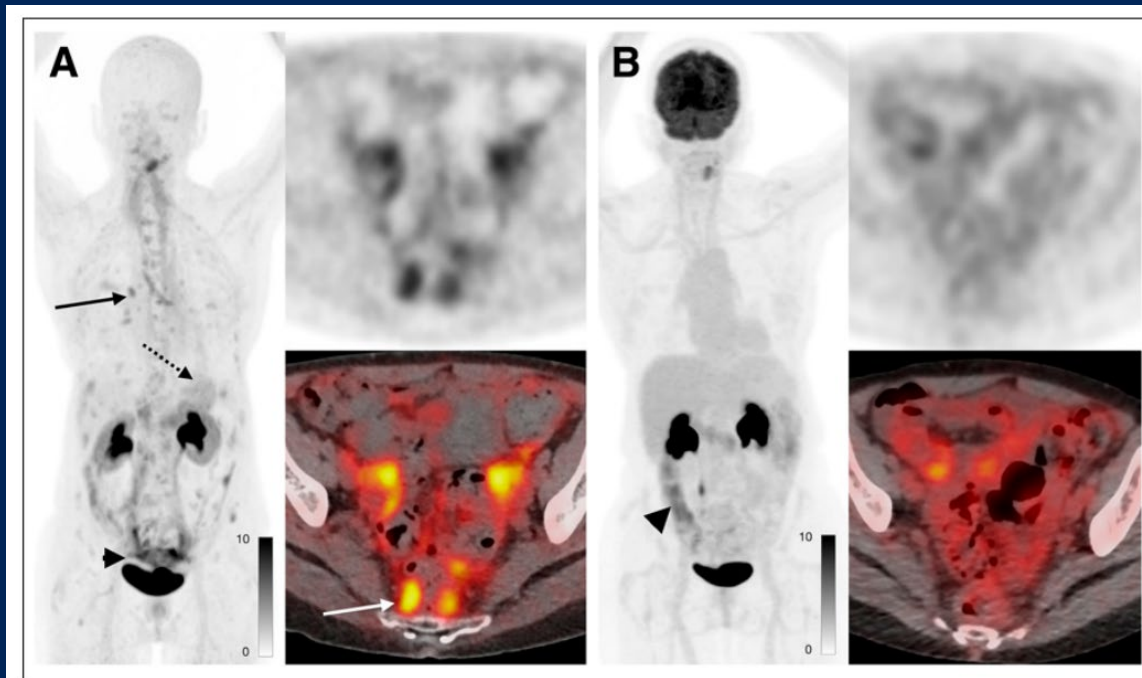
A 72-y-old woman with metastatic invasive lobular breast cancer. ^{68}Ga -FAP-2286 PET (A) revealed extensive metastatic disease not seen on ^{18}F -FDG PET (B), including small mediastinal and hilar lymph nodes (A, solid black arrow), diffuse gastric mucosal disease (A, dotted black arrow), and extensive peritoneal disease (SUV_{max} , 7.1; A, black arrowhead and white arrow). Uptake seen on ^{18}F -FDG PET in abdomen reflects physiologic uptake in bowel (B, black arrowhead) rather than tumor.
